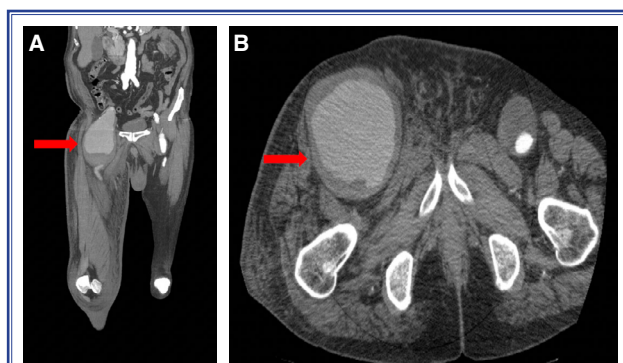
(A, B) A plain computed tomography image revealing a giant common femoral artery aneurysm (arrow).
